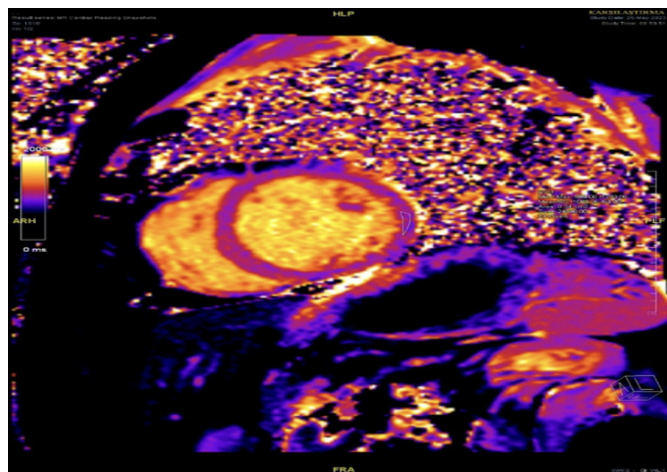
Cardiac magnetic resonance imaging (CMR) reveals mid-myocardial fibrosis in the septum, contrast uptake in the papillary muscles at the basal segments, and diffuse interstitial fibrosis in other myocardial segments.
